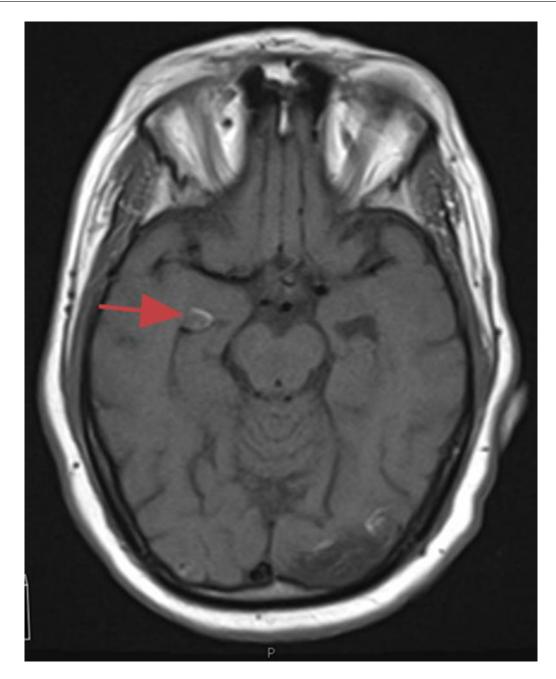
MRI brain without contrast demonstrating similar T1 hyperintense region with chemical shift artifact (shown here in right lateral ventricle) representing silicone oil.
